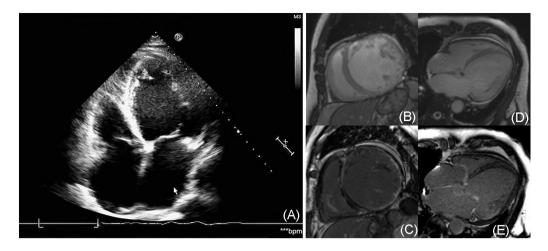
Echocardiography and cardiac MRI. (A) shows the decreased left ventricular systolic function (LVEF = 25%) and moderate pulmonary hypertension (pulmonary arterial pressure = 68 mmHg). (B-E) show the whole heart was enlarged mainly with left ventricular enlargement, decreased systolic function, and the left ventricular wall shows thinning and diffuse fibrosis.
